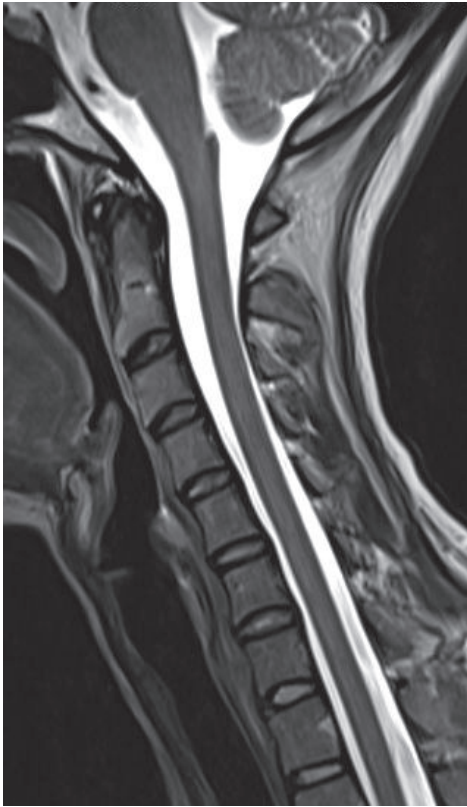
A midline sagittal T2-weighted image of the cervical spine. Note that the spinal cord is seen in its entirety; CSF is seen anterior and posterior to the spinal cord; and the vertebral bodies, odontoid process, and fourth ventricle are seen in profile.
